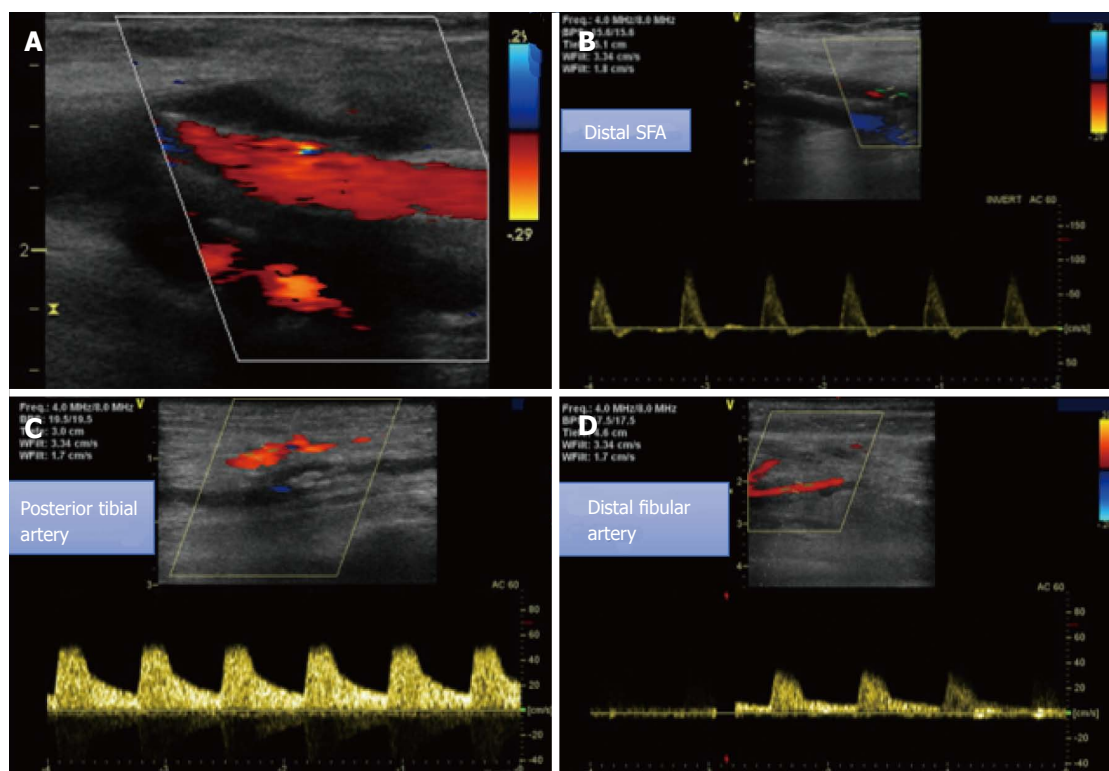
Duplex sonography at follow-up. A, B: Well perfused SFA with biphasic flow in the distal SFA and in the popliteal artery; C, D: Monophasic flow in the distal posterior tibial and fibular arteries. SFA: Superficial femoral artery.
